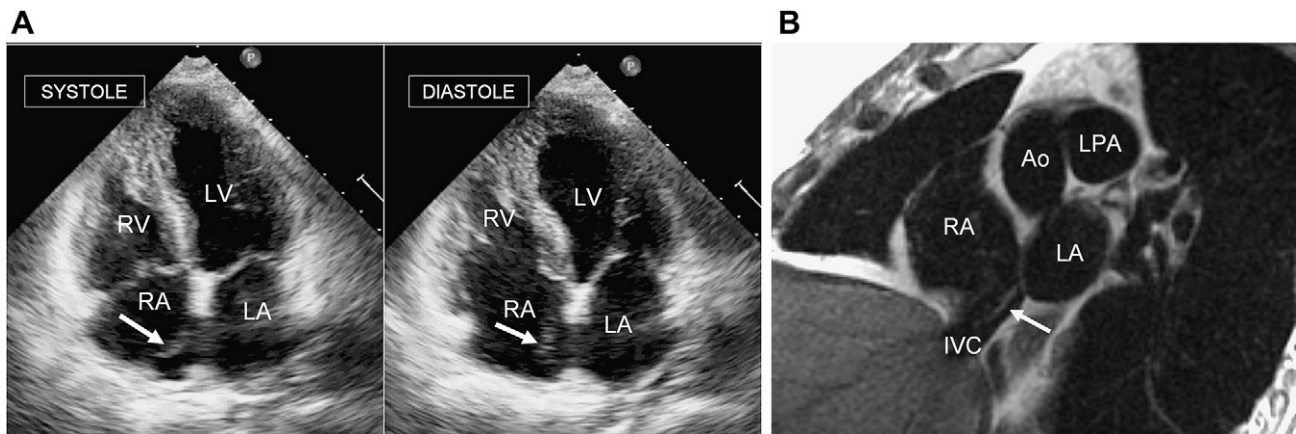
Echocardiographic apical 4-chamber views during systole and diastole (A) show a small mobile linear echogenic structure in the right atrium consistent with a Chiari network (arrow). Coronal oblique double inversion recovery T1-weighted MR image (B) from the same patient shows the Chiari network (arrow) as a linear structure, isointense with soft tissue, extending from the IVC-right atrial junction to the interatrial septum. RA, right atrium; LA, left atrium; LV, left ventricle; RV, right ventricle; Ao, aorta; IVC, inferior vena cava; LPA, left pulmonary artery.
